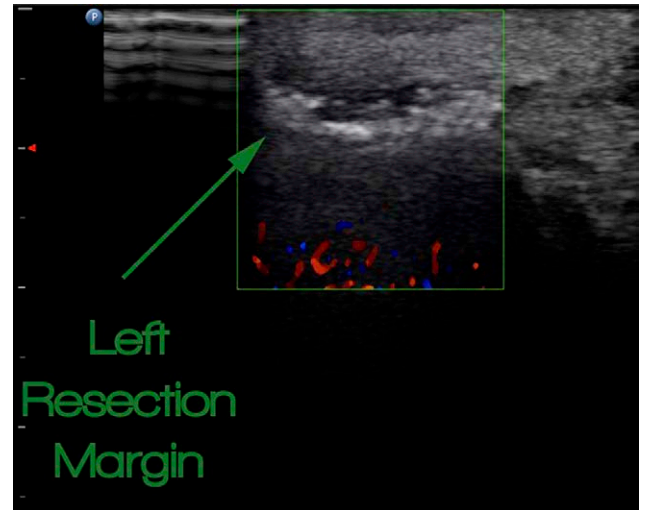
CDUS of the soft tissues beyond the left margin. CDUS indicates Color Doppler Ultrasound.
